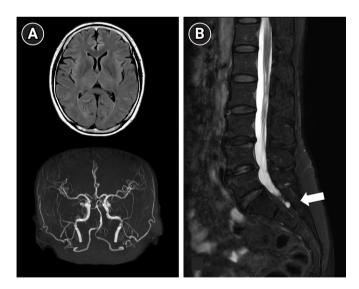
Imaging findings of the patient. (A) Normal brain magnetic resonance imaging (MRI) and magnetic resonance angiography taken 8 days after the initial thunderclap headache. (B) Spine MRI revealed a Tarlov cyst (white arrow), which is commonly reported in patients with persistent genital arousal disorder.
